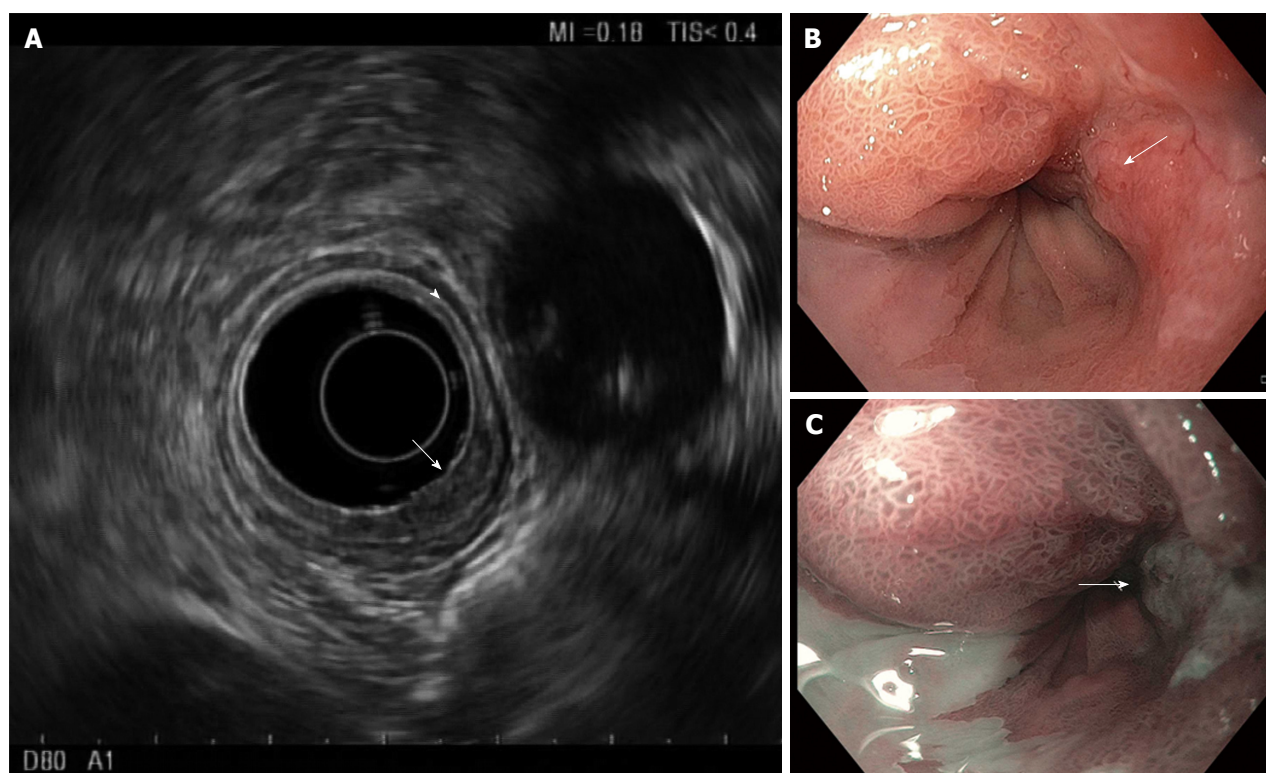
Endosonography of distal esophageal adenocarcinoma. A: Five layers of the esophagus are visible with standard frequency (7.5 MHz) endoscopic ultrasound. From innermost to outermost: the hyperechoic (bright) superficial mucosa, hypoechoic (dark) deep mucosa, the submucosa (arrowhead), followed by the muscularis propria (hypoechoic, very dark), and adventitia (outer echogenic layer). The T1b adenocarcinoma (arrow) causes thickening and distortion of the mucosal layers and submucosa, without invasion of the muscularis propria; B: White-light; and C: Narrow band images are presented for comparison, with arrows to mark the cancer.
